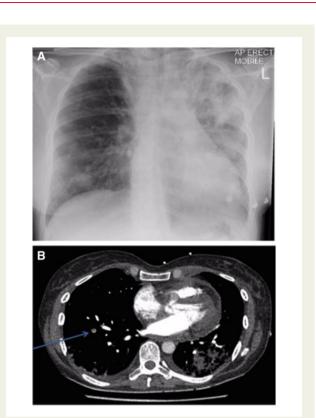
(A) Chest x-ray showing extensive left upper and middle zone sided consolidation. (B) Computed tomography pulmonary angiogram showing left-sided consolidation and small right-sided filling defect (arrow).
